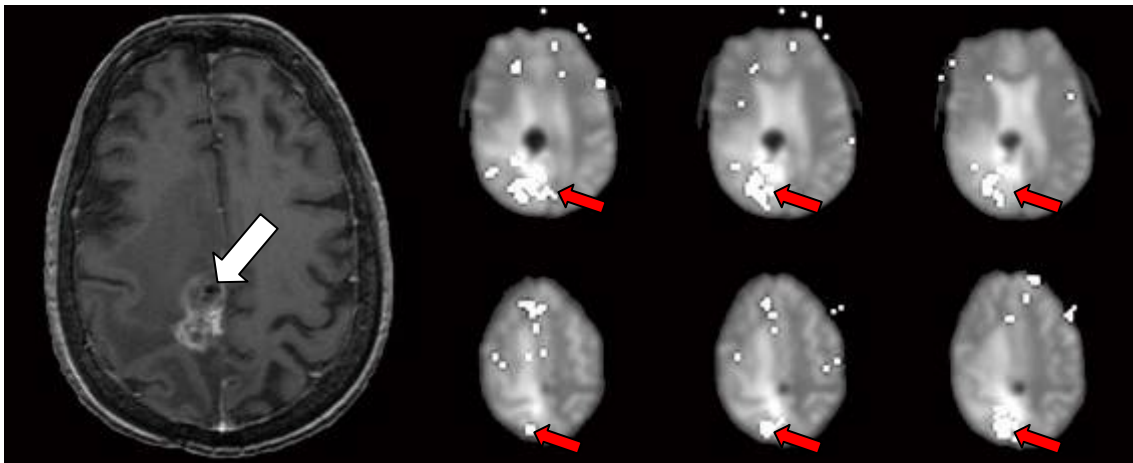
MRI with contrast enhancement showing a tumor (white arrow) in the right motorcortex (large image on the left) and the posterior displacement of the functional area of the left foot (red arrows) visualized in t-maps of BOLD images (six images on the right).
